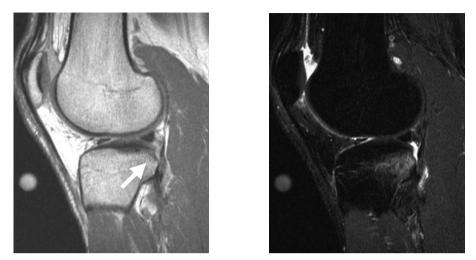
A cortical depression fracture, as visualized on MRI, located in the lateral tibial condyle in one of the knees assessed in this study (study id: KA1086). A line with low signal and parallel to a depressed cortex indicating trabecular fracture as well as a clear impression of the cortical bone (arrow) as visualized on the proton density weighted image of the dual echo turbo spin echo (DETSE) sequence (left) surrounded by BML as visualized on one image of the short tau inversion recovery (STIR) sequence (right). On both images the depressed cortex without cortical discontinuity is visualized.
